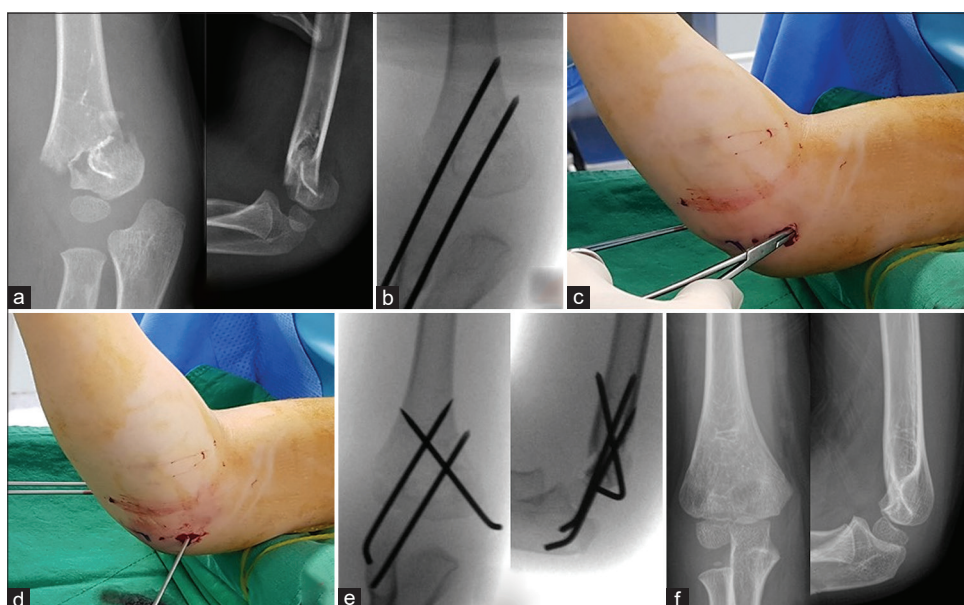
A 4-year-old boy sustained a type III supracondylar humeral fracture (a). After closed reduction, two lateral pins were inserted first (b). Then, a small incision was made over the medial epicondyle (c). An additional medial pin was inserted with the elbow at about 45° of flexion (d). Post-operative radiographs show a satisfactory reduction (e). A successful healing was achieved without loss of the reduction (f).
